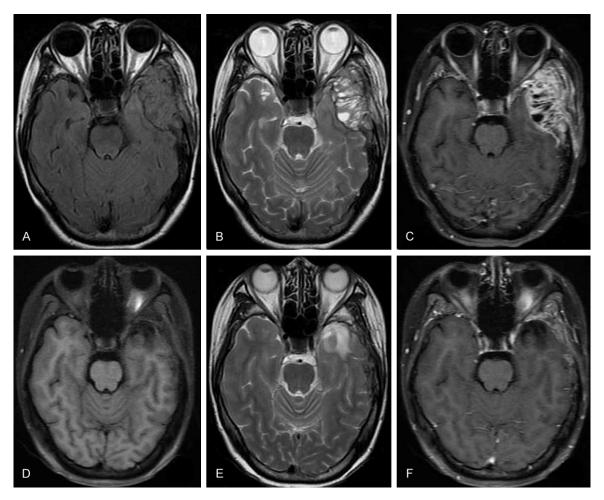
A: T1-weighted axial MRI reveals a 55*24 mm iso- and hypointense mass in the left temporal base, with a wide base adhering to the temporal bone. B: T2-weighted axial MRI reveals a mixed hyperintense mass, which erode left temporal bone. C: T1-weighted gadolinium-enhanced MRI image shows an irregular contrast enhancement in the tumor and part of temporal bone. D: T1-weighted axial MRI shows the mass had obviously contracted, though there is small encephalomalacia on part of the left temporal lobe. E: T2-weighted MRI shows encephalomalacia on part of left temporal lobe with high signal. F: T1-weighted enhanced axial MRI shows there is no evidence of tumor exists except a mild enhancement in part of left temporal bone.
